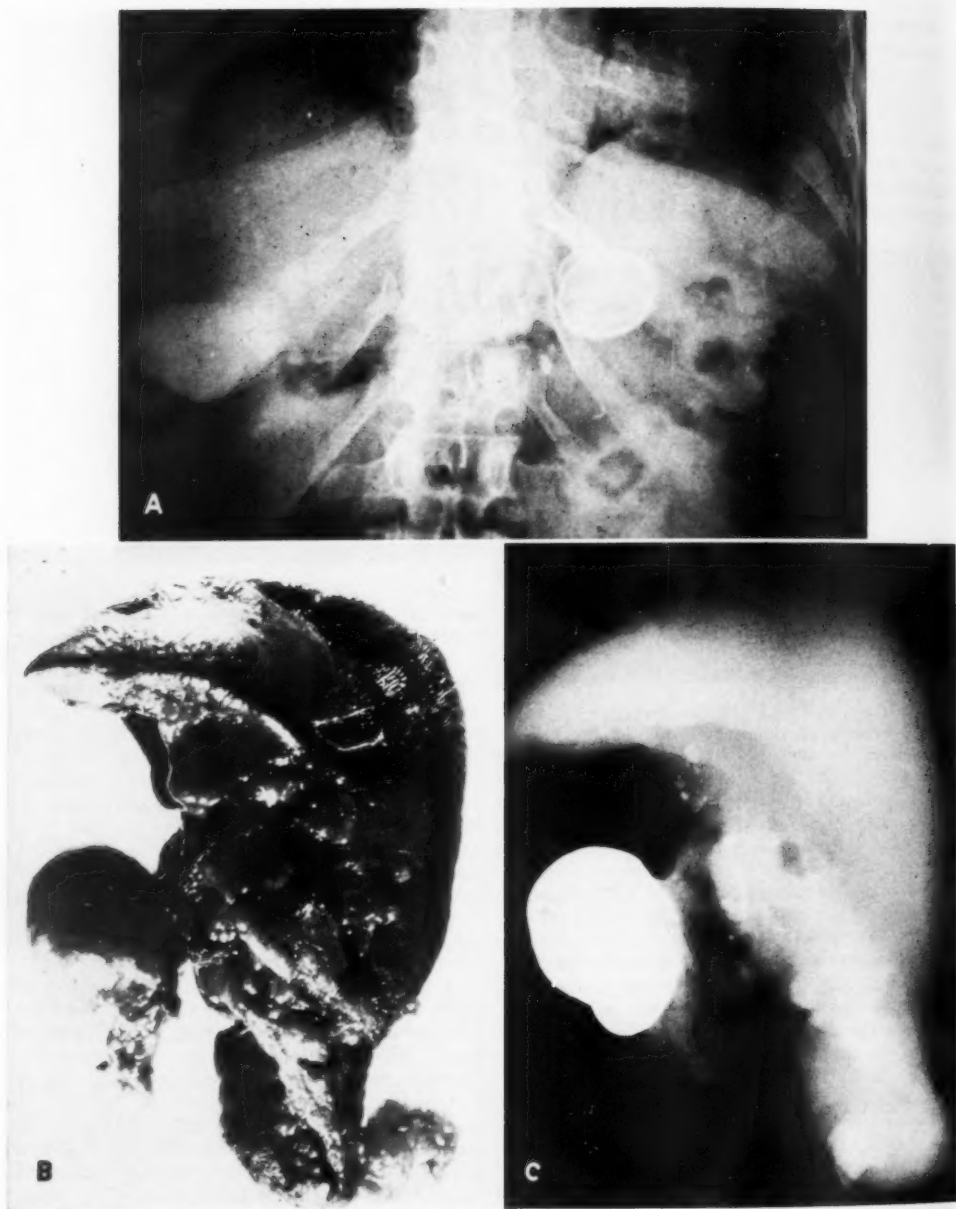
Case IV. A. Calcified splenic artery aneurysm discovered incidentally on an oral cholecystogram. B and C. Photograph and roentgenogram of the aneurysm and the spleen.
